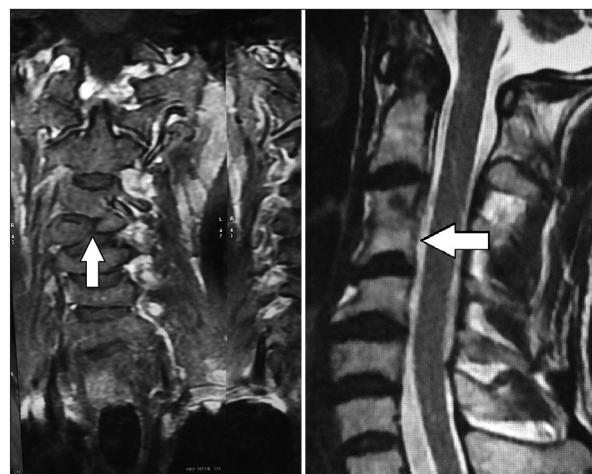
Magnetic resonance imaging cervical spine showing partial fusion of C3-4 without cord compression and butterfly vertebra at C4
